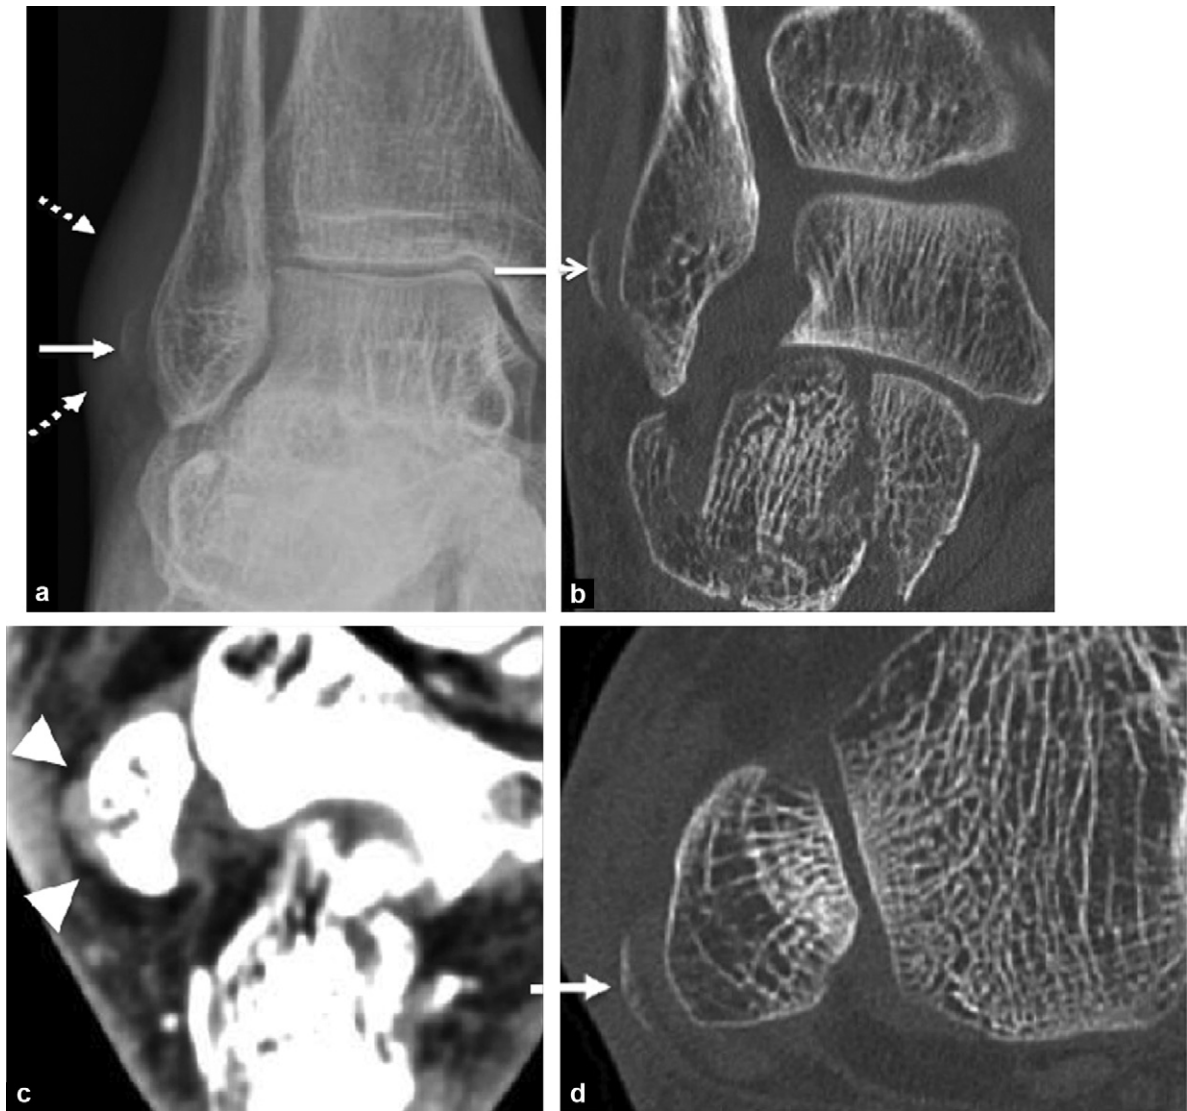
Dislocation of the fibular tendons. a: X-ray: tumefaction of the lateral peri-malleolar soft tissue (dotted arrow) associated with a bone avulsion (arrow); b, c, d: by scan in coronal section (b) and axial CT reformat (c and d). This avulsion corresponds to a tear of the fibular retinaculum (tip of arrow). In addition, there is a fracture of the calcaneus.
